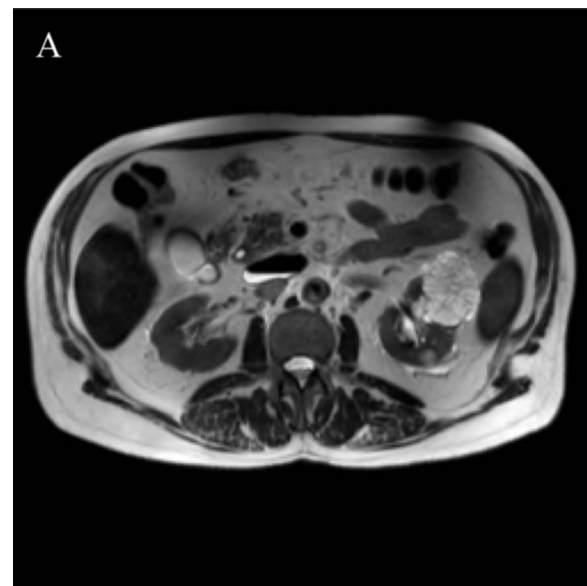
Repeat magnetic resonance imaging after 6 months shows an increase in the size of the left kidney lesion on (a) a T2-weighted image and (b) delayed postcontrast gadolinium-enhanced images
